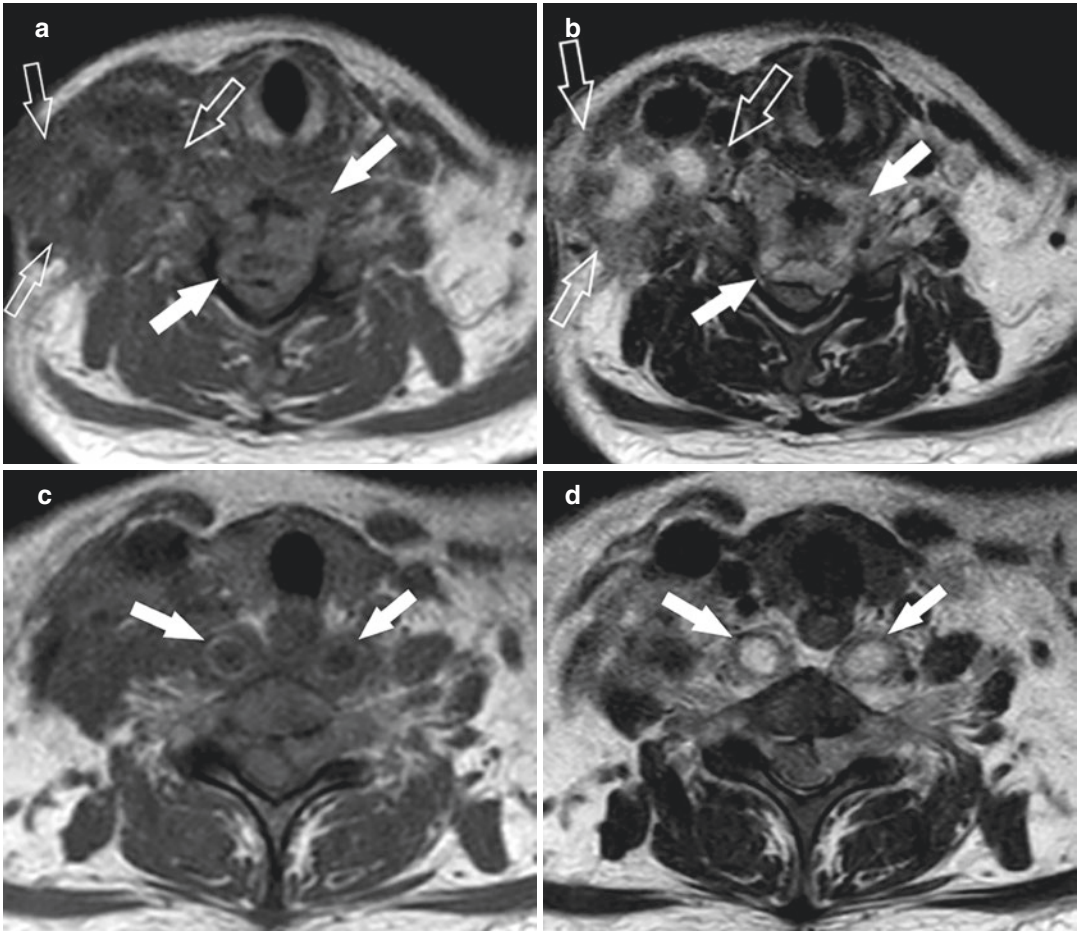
Tuberculous neck abscesses in a woman who has underlying end-stage renal disease with disseminated TB of the brain, lung, lymph nodes, spine, and adrenal glands. Axial (a) T1-W and (b) T2-W MR images show a right neck abscess, which is T1-hypointense and T2-hyperintense at the center and has an irregular T1-hyperintense and T2-hypointense rim (open arrows). The patient also has tuberculous spondylodiscitis with a
